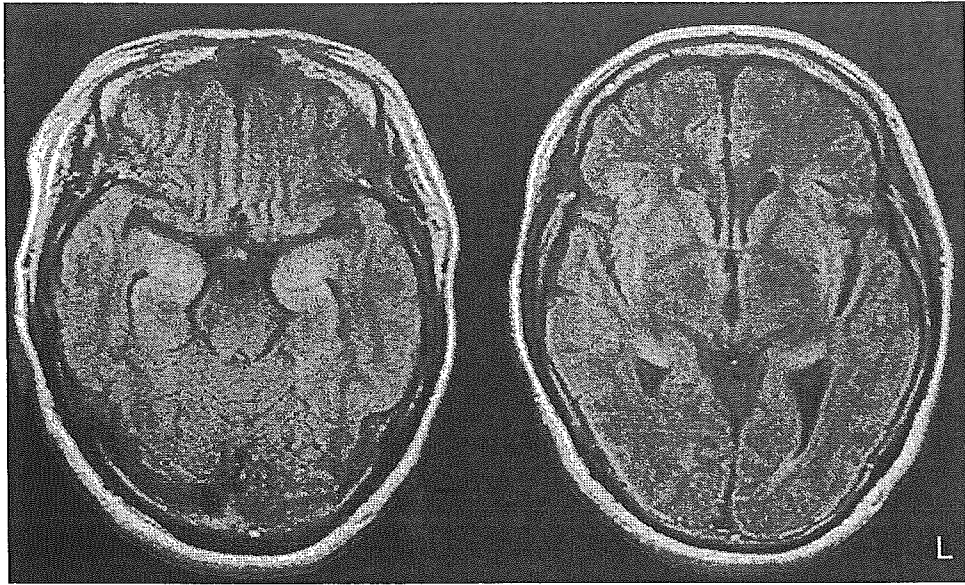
FLAIR MRI images. High signal intensity is seen in the bilateral medial temporal lobe and the lateral part of the putamen.
